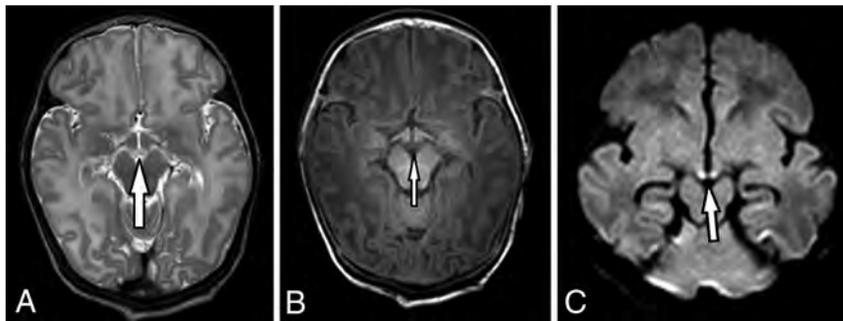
Arrows indicate the following: abnormally high-signal MBs on an axial T2-weighted image (A); abnormally low-signal MBs on an axial T1-weighted image (B); and abnormally high-signal MBs on DWI, b-value = 1000, accompanied by low ADC (not shown) (C).
